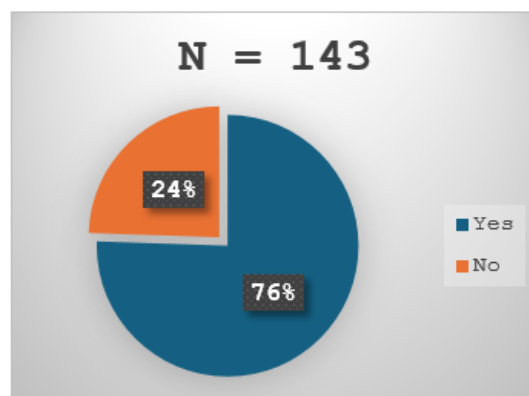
Proportion of prescribers informing patients of the risks of x-rays
